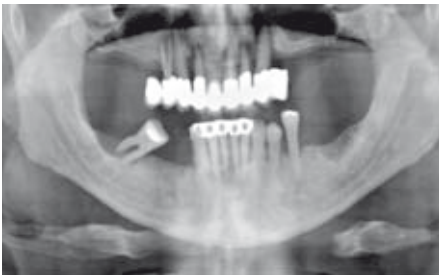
Radiographic evaluation of the initial situation.
